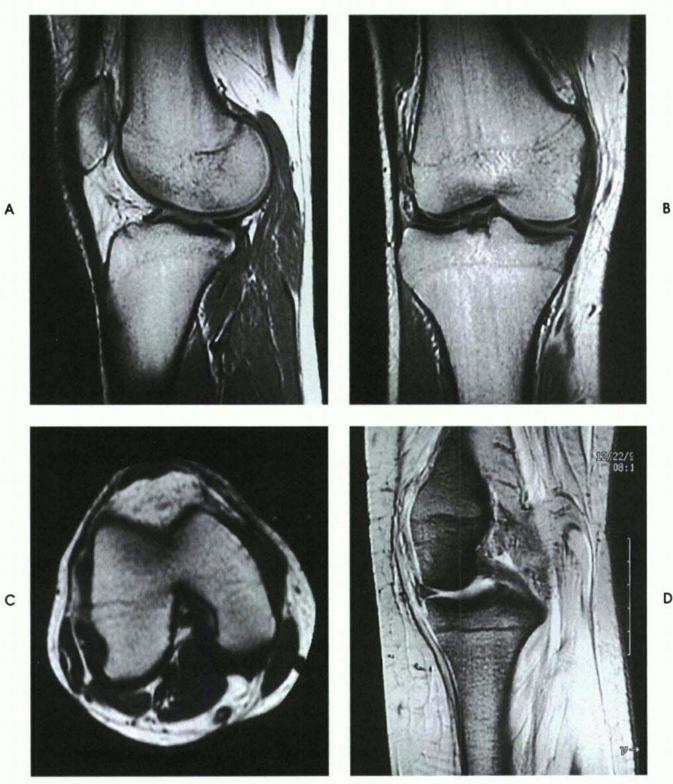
Magnetic resonance images of the knee in four planes. A, Sagittal. B, Coronal. C, Horizontal. D, Oblique, 45 degrees.
